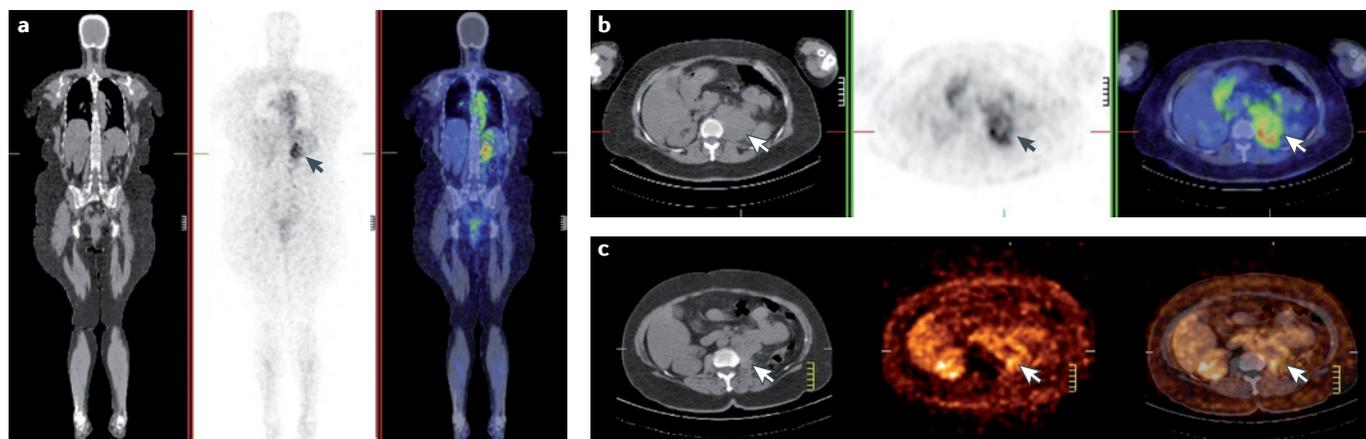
Biodistribution and pharmacodynamics of an antibody in vivo. a | Whole-body coronal positron emission tomography–computed tomography (PET–CT) images of ^{124}I -labelled cG250 (carbonic anhydrase IX (CAIX)-specific) monoclonal antibody, obtained 5 days after antibody infusion. The specific uptake of the antibody can be seen in the left renal tumour (arrow), which is expressing CAIX antigen. A quantitative concentration of an antibody in a tumour can be measured using this imaging methodology. Some normal blood pool activity can also be seen, owing to the antibody circulating in blood, but no other tissues show antibody localization. b | Transaxial PET–CT images through the left kidney mass, showing antibody localization in the tumour in detail (arrow). The right-hand panel shows combined (fused) PET–CT images. c | A quantitative tumour blood flow assessment using $\text{H}_2\ ^{15}\text{O}$ PET–CT. Tumour perfusion is readily apparent (arrow) in the left kidney mass. Pharmacodynamic changes in the tumour following treatment can be assessed non-invasively using imaging techniques.
